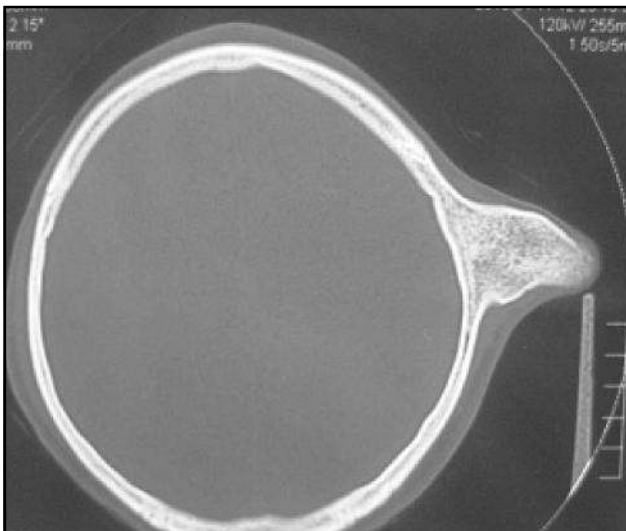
CT scan of the skull showing the bony tumor arising from the outer table of the skull vault
